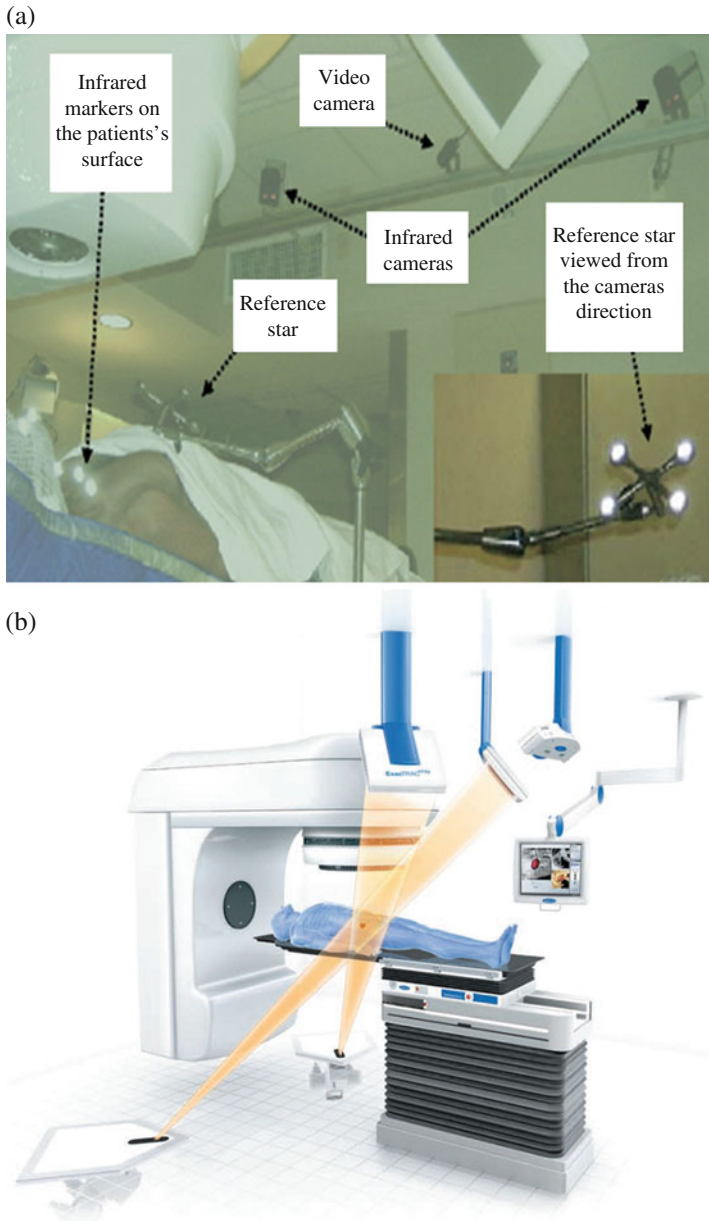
(a) The infrared camera-based ExacTrac system; (b) the Novalis body image-guided system showing the X-ray imaging devices (Jin et al. 2008)
